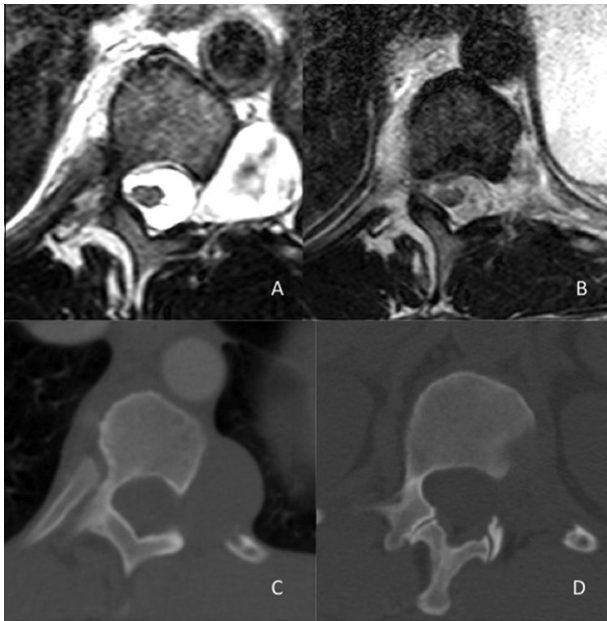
(A) Preoperative and (B) postoperative axial MRI and (C) preoperative and (D) postoperative axial CT scans showing a T11/12 neurofibroma resected through the minimally invasive lateral retropleural approach.
